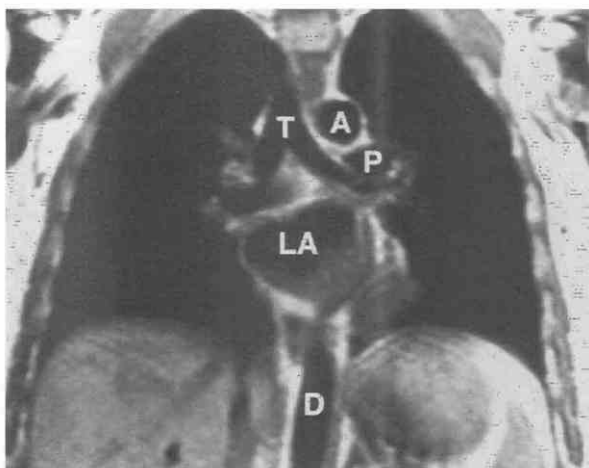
Coronal MR image at the carina. A, transverse aortic arch; D, descending aorta; LA, left atrium; P, left pulmonary artery; T, trachea.
